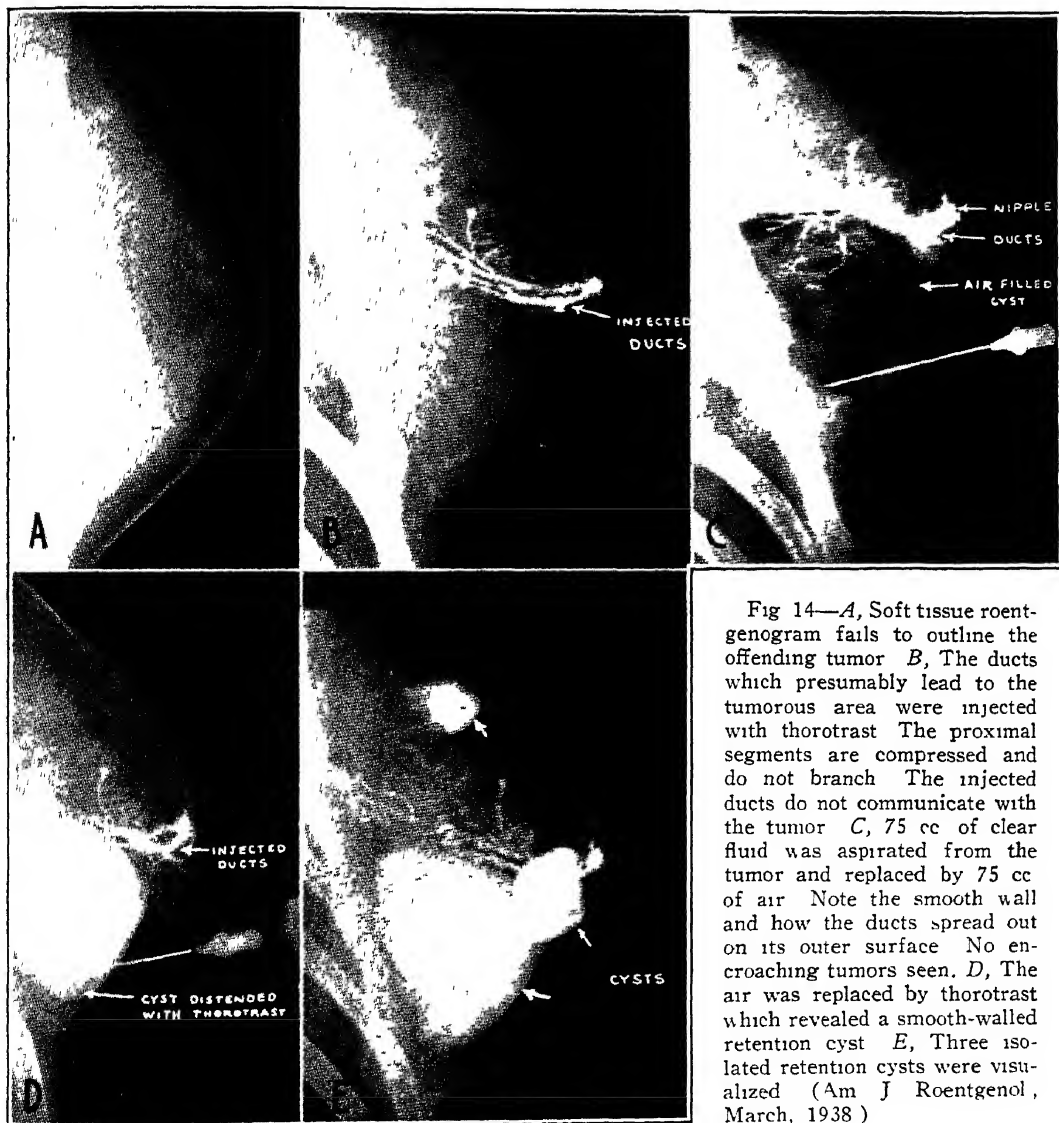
A, Soft tissue roentgenogram fails to outline the offending tumor B, The ducts which presumably lead to the tumorous area were injected with thorotrast. The proximal segments are compressed and do not branch. The injected ducts do not communicate with the tumor C, 75 cc of clear fluid was aspirated from the tumor and replaced by 75 cc of air. Note the smooth wall and how the ducts spread out on its outer surface. No encroaching tumors seen. D, The air was replaced by thorotrast which revealed a smooth-walled retention cyst. E, Three isolated retention cysts were visualized. (Am J Roentgenol, March, 1938.)
